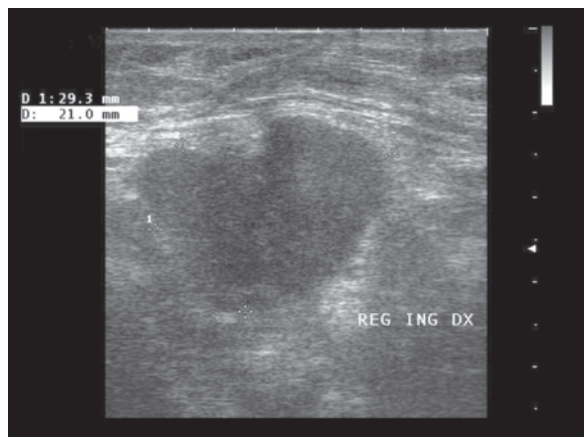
b Metastasis of the iliopubic eminence from lung cancer. US study of a patient with newly diagnosed lung cancer and inguinal soreness shows a hypoechoic mass incorporating the interrupted bony structures (a). CT scan confirms the mass protruding into the deep soft tissue of the inguinal region (b, arrow)
